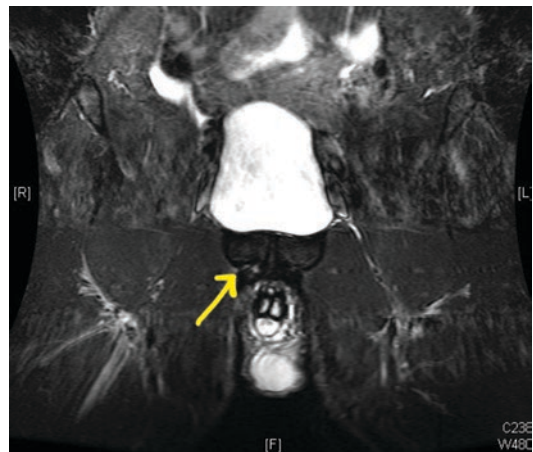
MRI of the pelvis of a male ATP tennis player who had limited hip range of motion consistent with femoroacetabular impingement. However, he had no hip pain, and this MRI demonstrates a core muscle injury on the right (Arrow). (Image used with permission from Marc R. Safran, MD)
